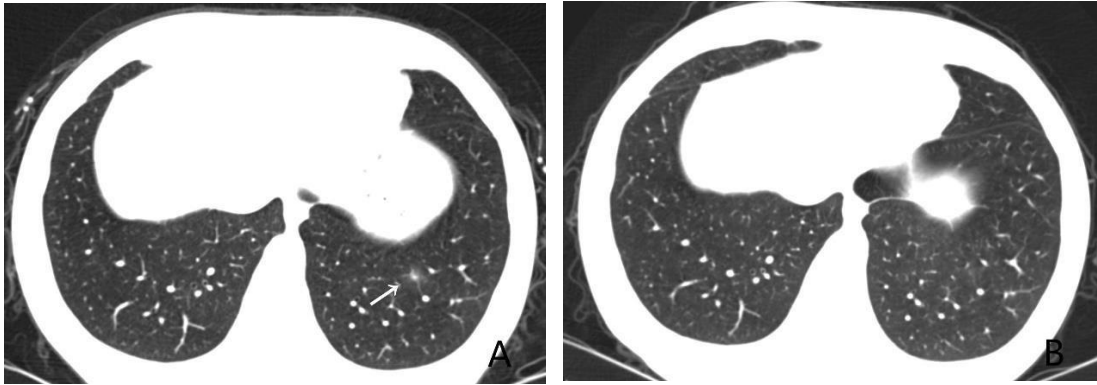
A: COVID-19 patient, male, 51years old, CT images on the 17th day of onset. Single ground glass nodules in the left lower lung (arrow). B: The same patient with figure A, CT images on the 31th day of onset. The left lower lung disease was completely absorbed.
